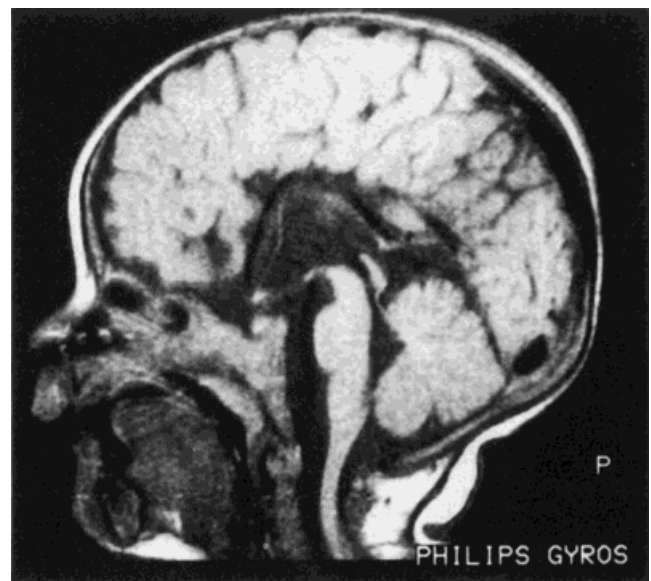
Agenesis of the corpus callosum (MRI).
